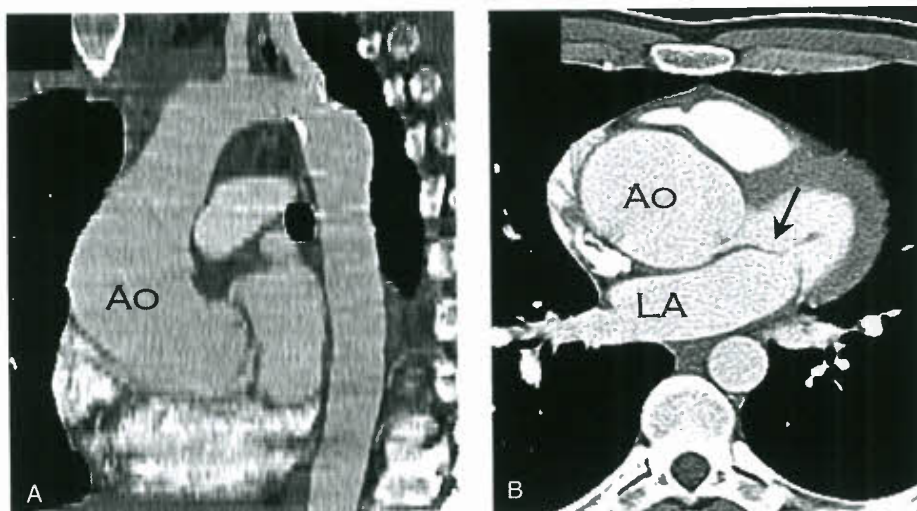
Computed tomography images of dilated aortic root in a patient with bicuspid (but not stenotic or regurgitant) aortic valve. The patient has had repair of coarctation of the aorta. A: Sagittal view. B: Axial view. Ao, aorta; LA, left atrium; black arrow, anterior mitral valve leaflet.
